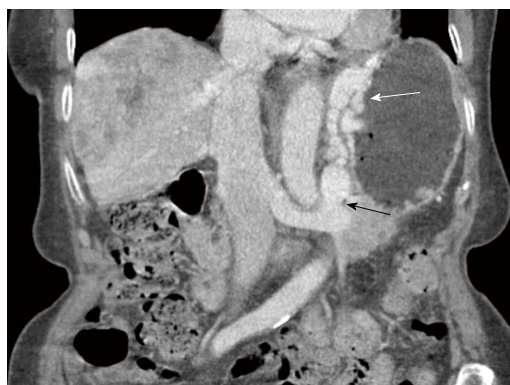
Coronal enhanced computed tomography image demonstrates a large gastrorenal shunt (black arrow) and perigastric, as well as, gastric submucosal varices (white arrow) in a patient with liver cirrhosis and portal hypertension.
